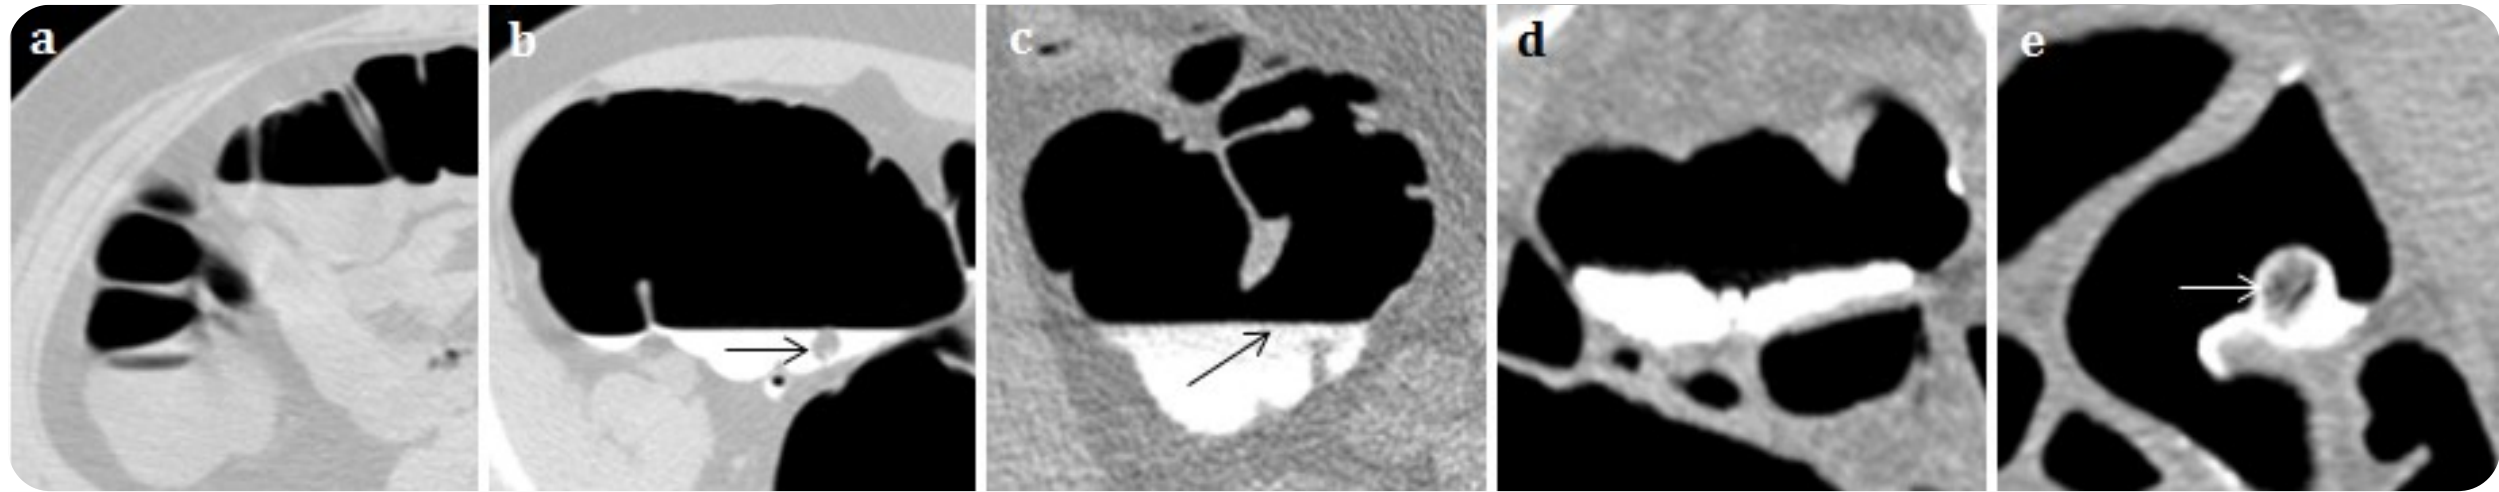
Different clinical cases of CT colonography technique. Fecal tagged images viewed with window values W,C = 1400, -350 (<https://shodhganga.inflibnet.ac.in/handle/10603/180708>)
